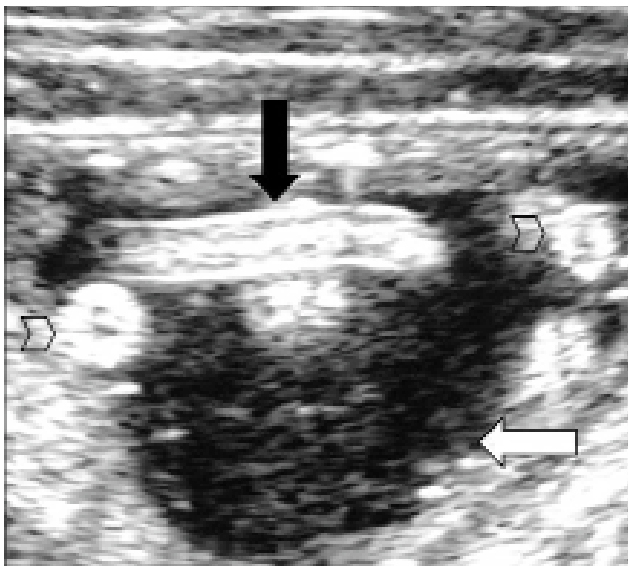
Abdominal ultrasound using a linear probe showing multiple Ascaris worms with bull's eye (cross-section of worms, arrow heads) and railway appearance (longitudinal section of worms, black arrow) within the lumen of the small bowel (white arrow).
